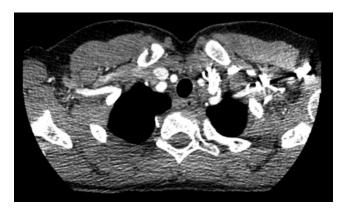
Axial postcontrast CT slice shows the infiltration of the dysplastic tissue into the bone.
